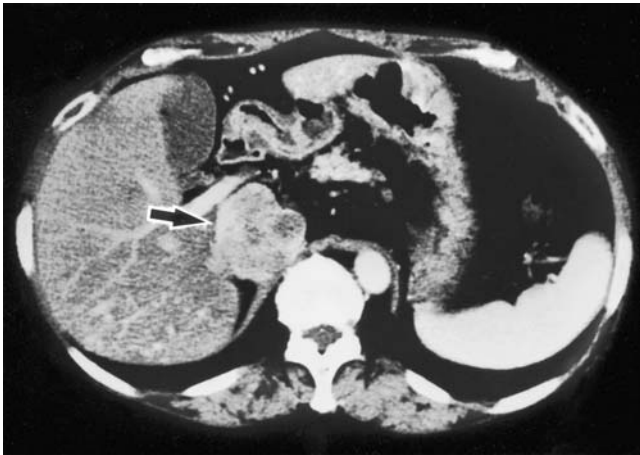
Computed tomography (CT) shows a mass compressing the inferior vena cava (IVC) (arrow) to the right ventral side in the retrohepatic portion of the IVC
